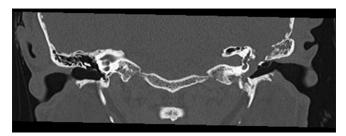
Coronal reformat of petrous temporal computed tomography scan depicts bony defect in left tegmen tympani associated with opacity in the middle ear and lateral displacement of ossicles
